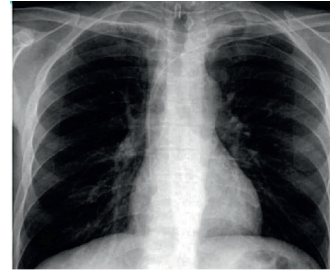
Chest X-ray to determine the position of the catheter tip.
